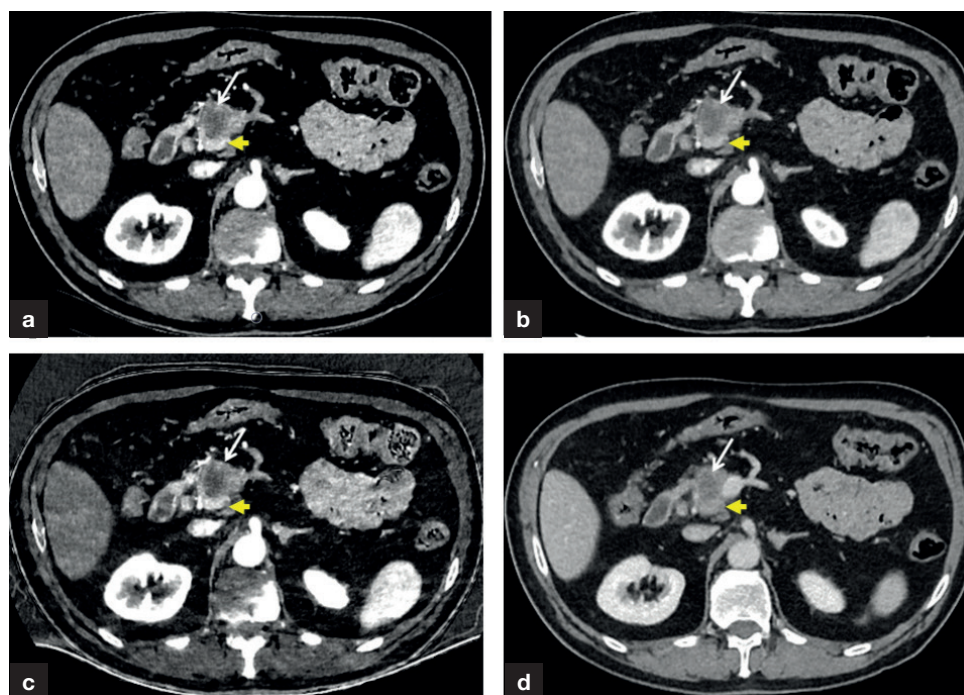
Dual-energy computed tomography images of ductal adenocarcinoma of the pancreatic head. a. Arterial phase axial computed tomography 50 keV and (b) 70 keV post-processed images. There is greater contrast between the tumour (white arrows) and normal adjacent pancreatic parenchyma (yellow arrows) on the lower 50 keV image, which is closer to the k-edge of iodine, but the image produced is noisier. c. Iodine-perfusion map showing similar increased conspicuity of the tumour compared to (d) the more conventional portal venous phase computed tomography image.
